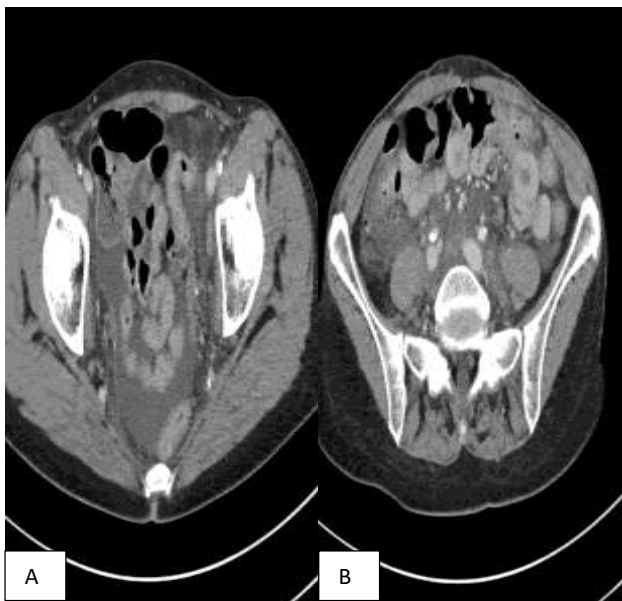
(A and B): Computed tomography showed a large amount of intraperitoneal and retroperitoneal fluid and small bowel thickening, which is non-specific.
